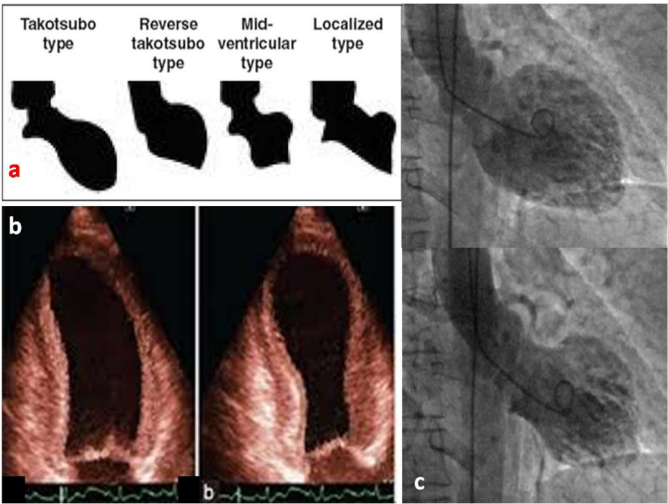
a. Wall motion abnormality patterns in TTS. b. characteristic apical ballooning in echocardiography. c. apical ballooning in left ventriculography
